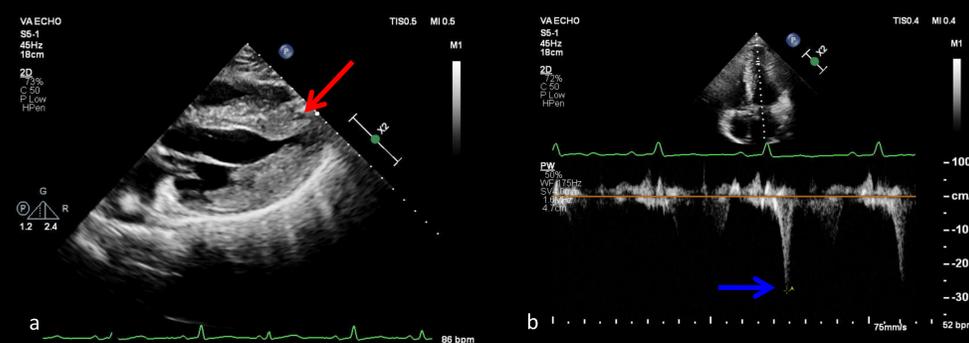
Transthoracic echocardiogram subcostal window (a) showing left ventricle with predominant apical hypertrophy (red arrow). Spectral pulse wave Doppler (b) showing an apical intracavitary gradient of 30mmHg (blue arrow).
